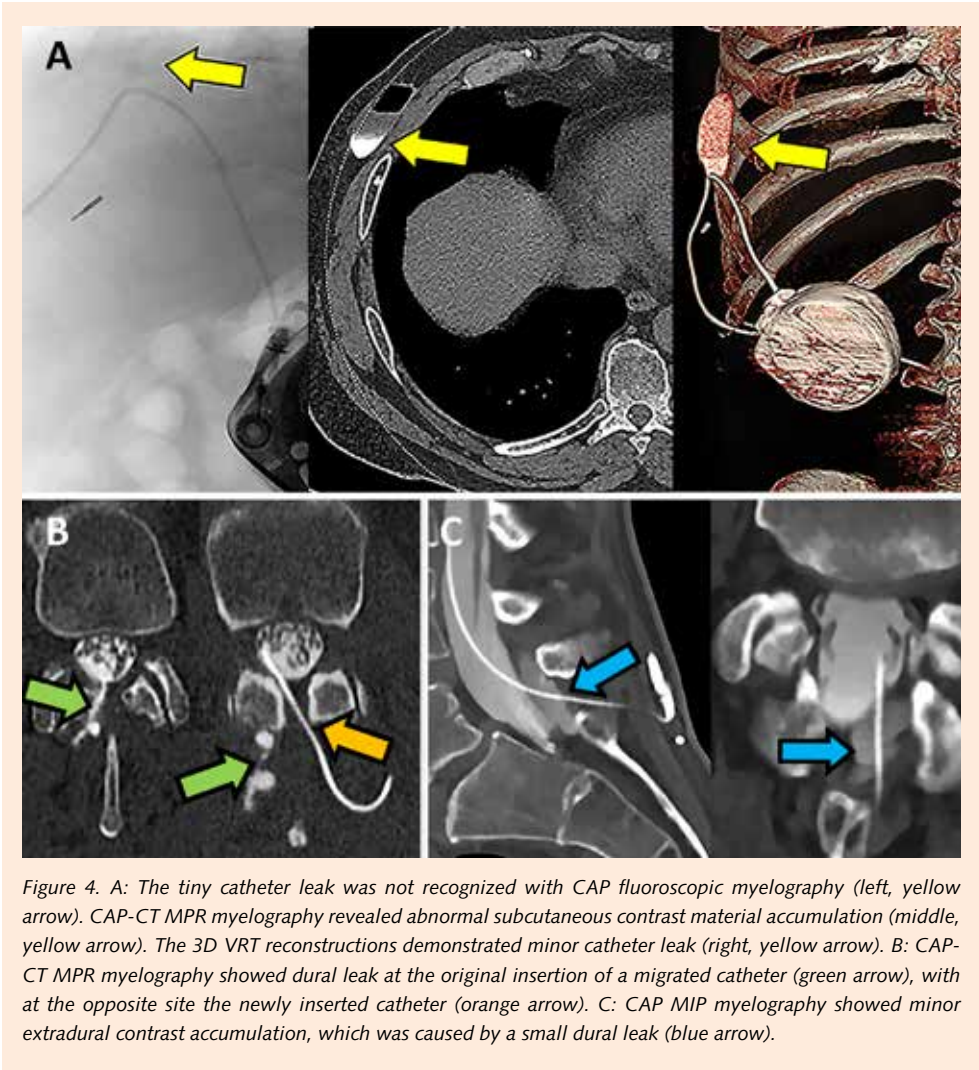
A: The tiny catheter leak was not recognized with CAP fluoroscopic myelography (left, yellow arrow). CAP-CT MPR myelography revealed abnormal subcutaneous contrast material accumulation (middle, yellow arrow). The 3D VRT reconstructions demonstrated minor catheter leak (right, yellow arrow). B: CAP-CT MPR myelography showed dural leak at the original insertion of a migrated catheter (green arrow), with at the opposite site the newly inserted catheter (orange arrow). C: CAP MIP myelography showed minor extradural contrast accumulation, which was caused by a small dural leak (blue arrow).
